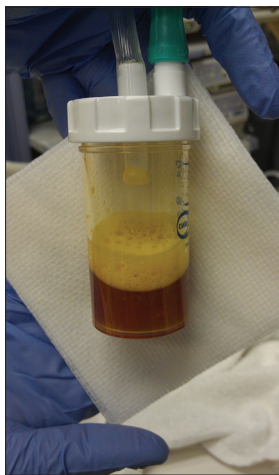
Photograph of yellow fluid (positive for bilirubin) aspirated from the right lower lobe during bronchoalveolar lavage on the same day as the technetium-99m mebrofenin cholescintigraphy study in Figures 3 and 4
